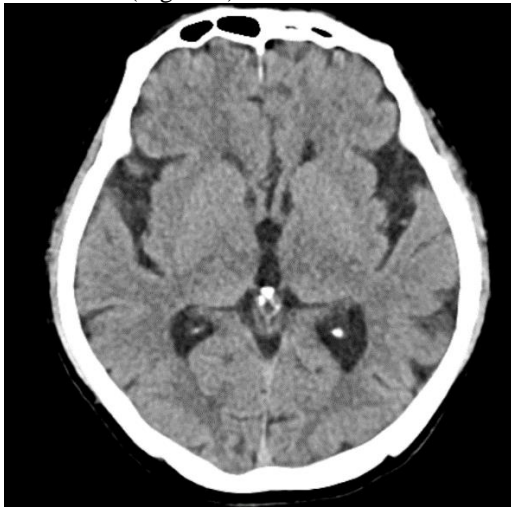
Plain CT Brain showing no evidence of any acute infarction.
